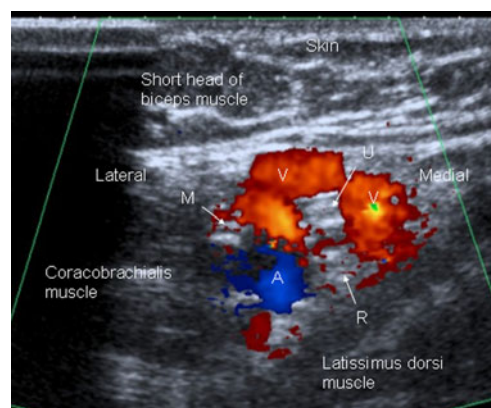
On the short-axis images, the axillary artery (AA) [A] is placed at the center of the image (coded in blue) and appears as a highly anechoic, circular and uncompressible structure on grayscale US images. The axillary vein (AV) [V] is located medial and anterior to the AA and the deep branch of the AV is located posterior to the AA (veins are coded in red). The Doppler function is used to better delineate the anatomical structures and can be used to identify AA or AV when in doubt. Brachial plexus nerves (median [M] (10 o'clock), ulnar [U] (2 o'clock) and radial [R] (4 o'clock) are located around the AA as relatively hypo-hyperechoic, multifibered circular cord-like structures surrounded by a mild hyperechogenic epineurium. Nerves appear as round small structures
